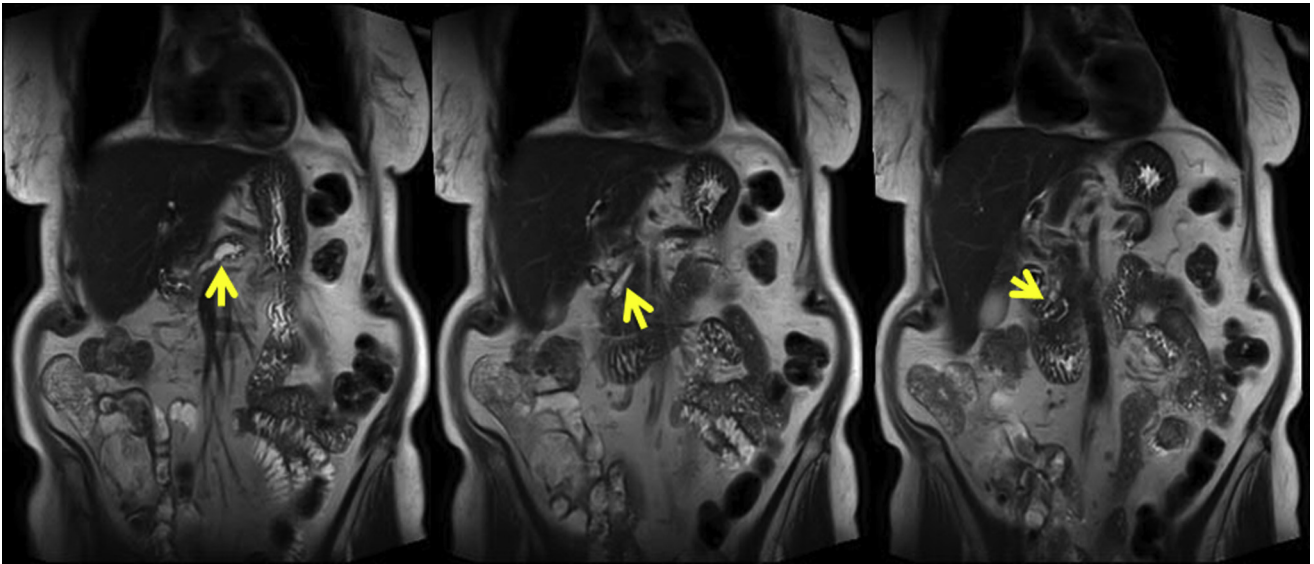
Repeat magnetic resonance imaging with MRCP after the third extracorporeal shockwave lithotripsy treatment demonstrated decreased pancreatic stone burden and decreased main duct dilation.
